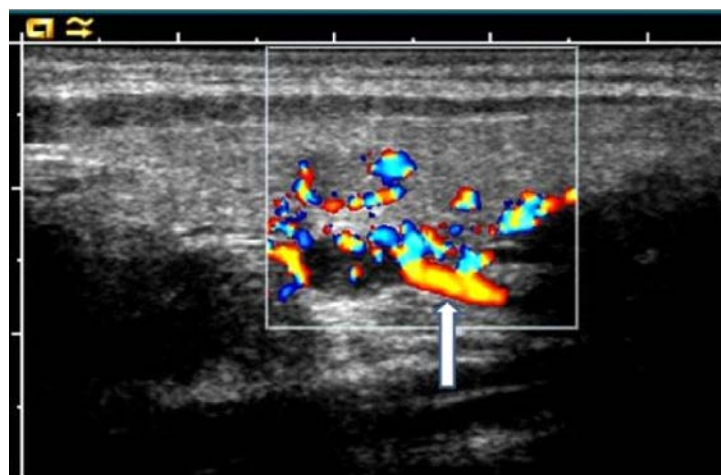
Adenoma (primary hyperparathyroidism – pHPT): Color Doppler of the right inferior parathyroid gland. Note an artery entering at the one pole of the gland. A thyroid parenchymal node with a typical intrathyroidal vascularization is visible above the parathyroid adenoma.
